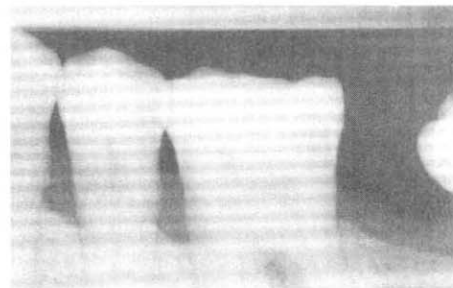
Radiograph with copper stepwedge
